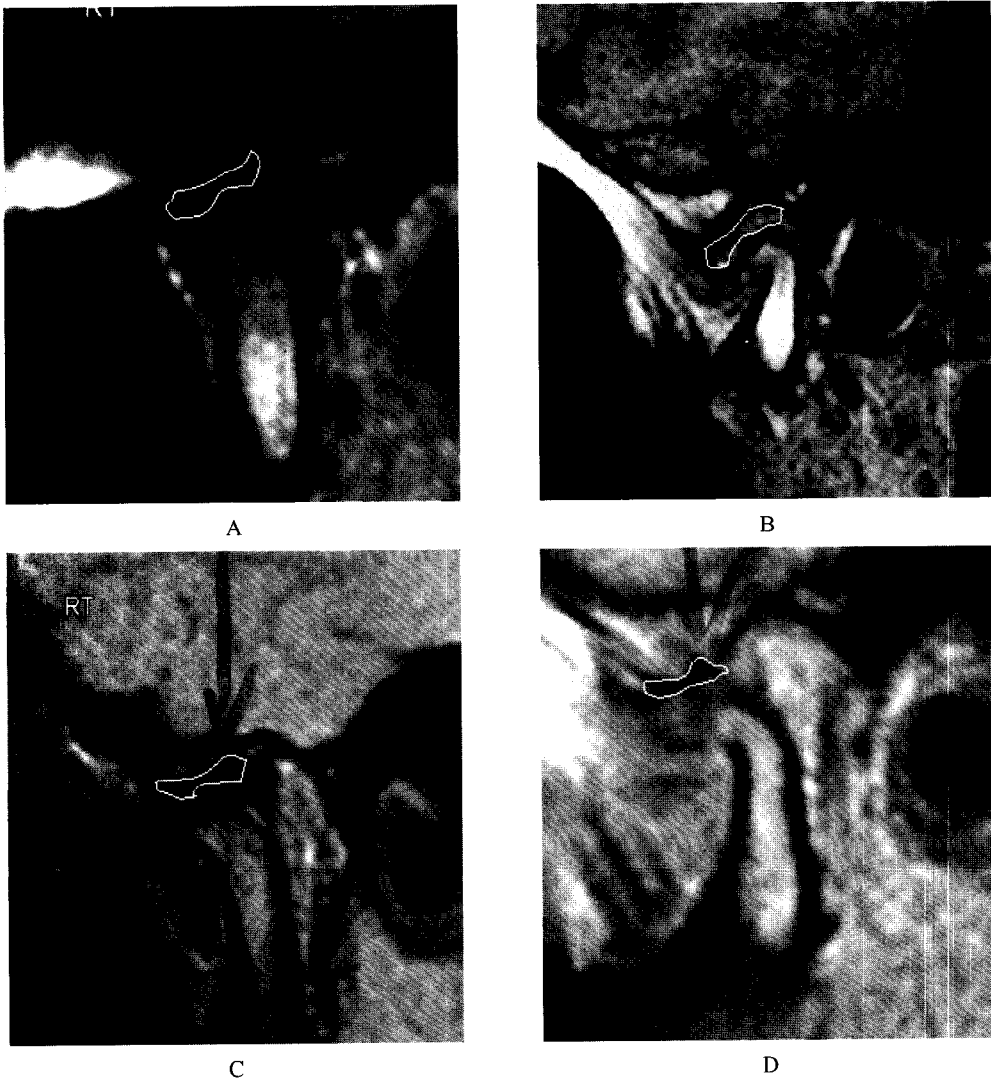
MRI finding of posttreatment in case 2
